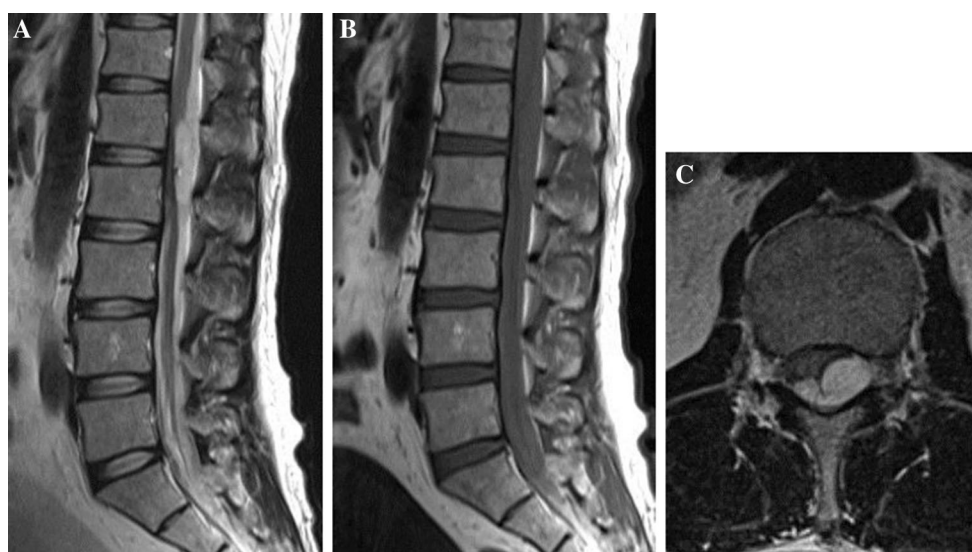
Case 1: preoperative images from a sagittal T2-weighted MRI, b sagittal T1-weighted MRI, and c axial T2-weighted MRI revealed a spinal subdural hematoma between L1 and L2
